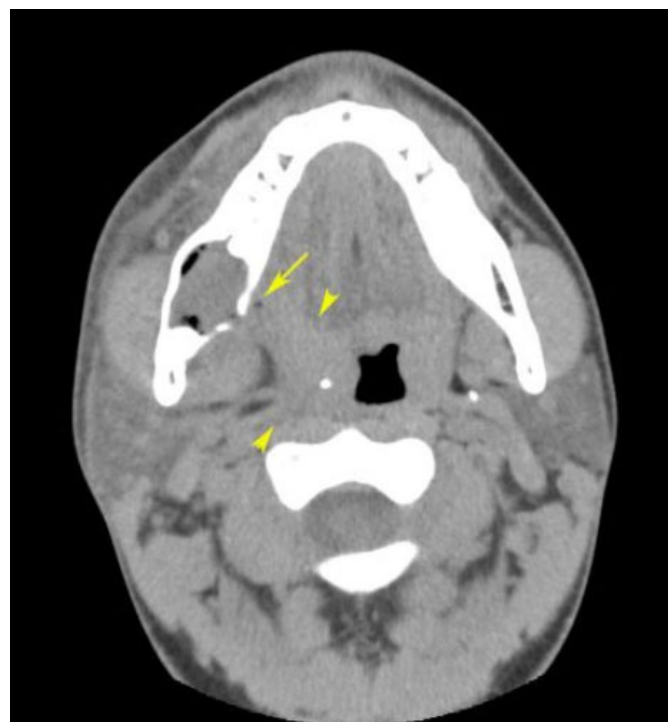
CT image at the initial visit showing gaseous content in the lingual region (arrow) and swelling of parapharyngeal space (arrowheads).
